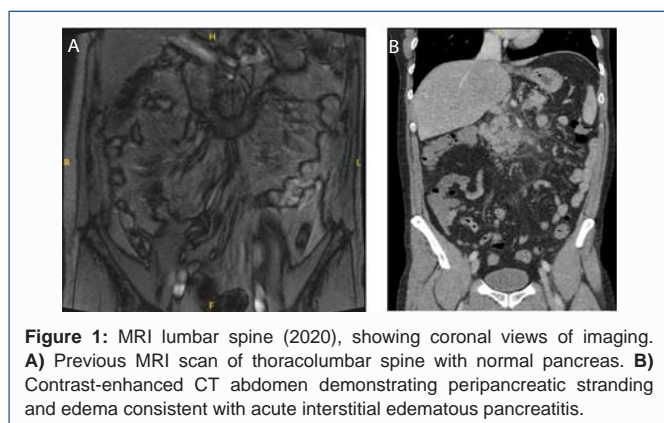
MRI lumbar spine (2020), showing coronal views of imaging. A) Previous MRI scan of thoracolumbar spine with normal pancreas. B) Contrast-enhanced CT abdomen demonstrating peripancreatic stranding and edema consistent with acute interstitial edematous pancreatitis.
